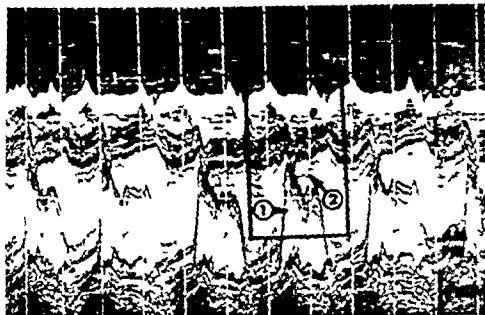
Echocardiogram of a 15-year-old girl with aortic regurgitation showing diastolic flutter of the mitral valve and ventricular septum. The anterior mitral leaflet exhibits both coarse and fine oscillations. Arrow No 1 points to mitral flutter and arrow No 2 to septal flutter. VS ventricular septum. AVF anterior mitral leaflet. PV posterior mitral leaflet. PWLV posterior wall of left ventricle.
